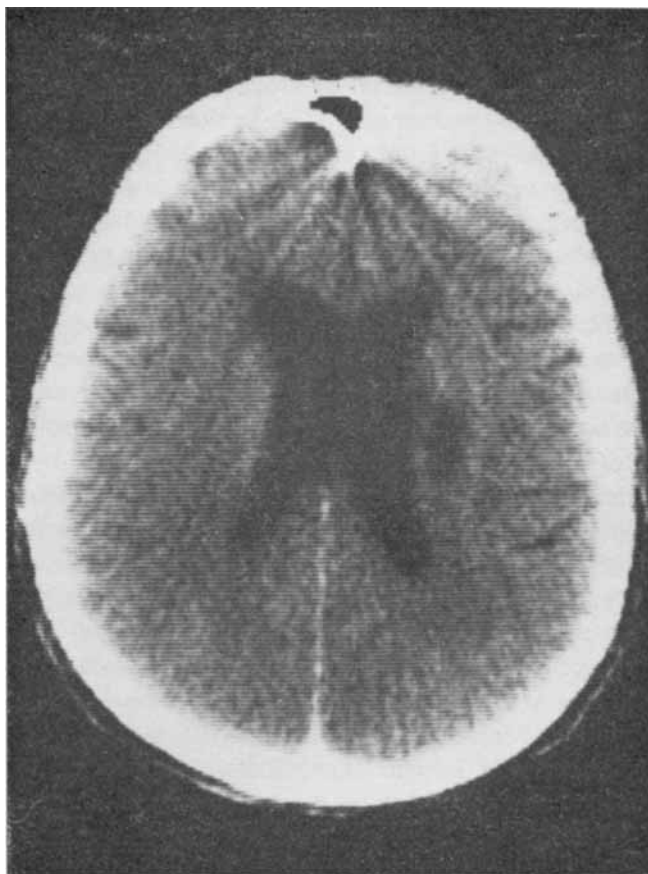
Computerized tomographic (CT) scan of patient No. 1, 1 year following completed stroke, revealing a dilatation of the ventricular system and a low-absorbing area in the right lenticular nuclei.
